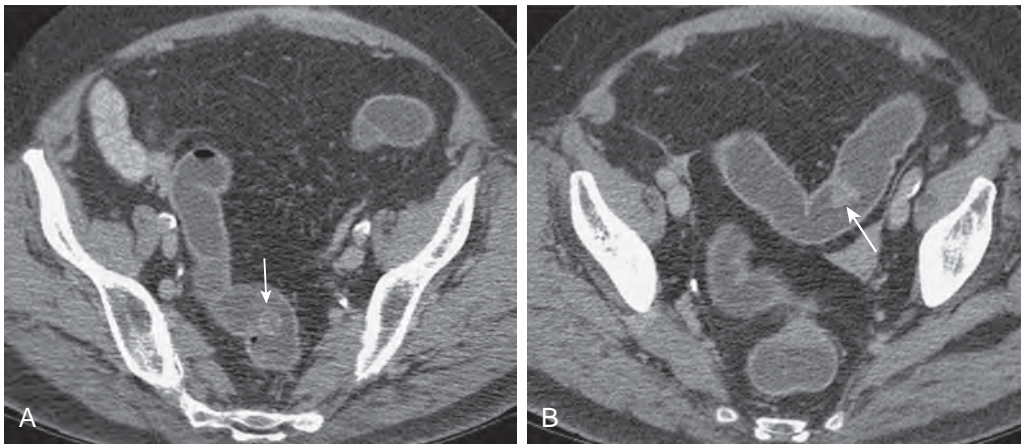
CT of benign polyps. A. Axial thin-section MDCT scan identifies a sessile polyp (arrow) on the left wall of the proximal sigmoid colon, which was confirmed by colonoscopy in a patient with carcinoma of the cecum and familial polyposis syndrome. B. Axial thin-section MDCT below level shown in A demonstrates a second polyp (arrow) in the small bowel.
